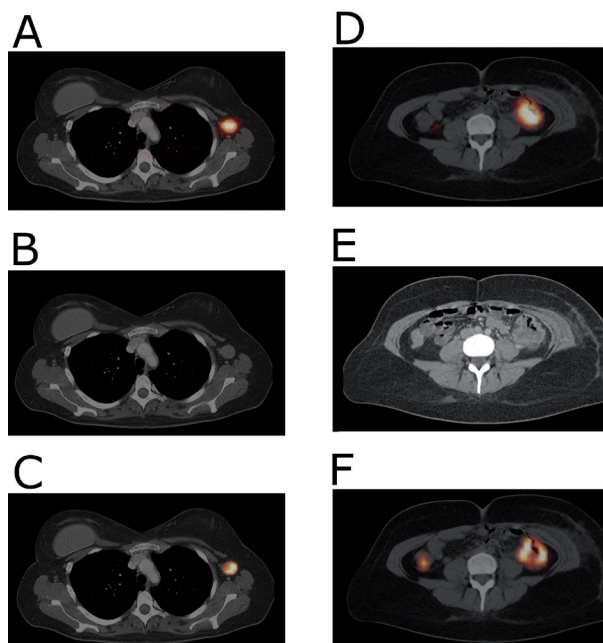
Scintigraphic images. The SPECT/CT image (A), acquired 24 h after injection of ^{111}In -IMP288 (185 MBq, 25 μg), pretargeted with 75 mg TF2 (1-day interval), in a 38-year-old patient (cohort 4), shows very clear tumour targeting of an axillary lymph node metastasis, with very low concentrations of radioactivity in normal tissues. Corresponding contrast-enhanced CT scan and a fused FDG-PET/CT scan are shown (B and C, respectively). The primary colon tumour (50 cm ab ano) also shows highly specific tumour targeting in the SPECT-image (D), confirmed by the CT-scan and FDG-PET/CT (E and F, respectively), with non-specific FDG-uptake in the ascending colon.
